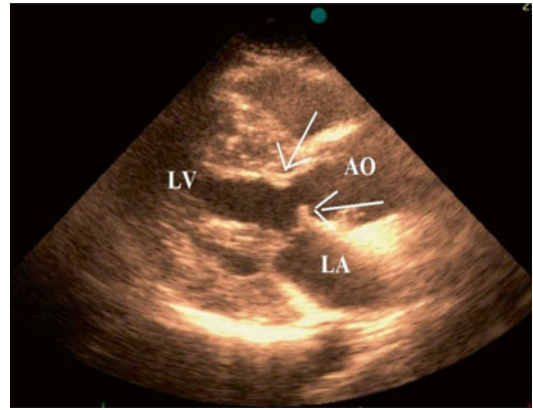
Parasternal long-axis view showing a discrete fibrous ring encircling the left ventricular (LV) outflow tract with extension to the anterior MV leaflet (white arrows). LA left atrium, AO aorta
